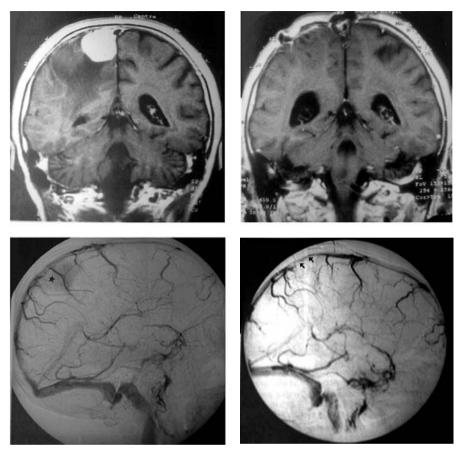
Type III mid-third parasagittal meningioma. *Upper left*: preoperative coronal Gd-enhanced T_1 -weighted MR image showing a right parasagittal meningioma with Type III invasion of right wall of the sinus. *Upper right*: postoperative coronal Gd-enhanced T_1 -weighted MR image showing no evidence of tumor remnant. The lateral sinus wall was resected and patched. *Lower left*: preoperative venous-phase angiogram, lateral view, demonstrating a patent sinus and tumor blush (*star*). *Lower right*: postoperative venous-phase angiogram, lateral view, demonstrating sinus patency (*arrows*)
